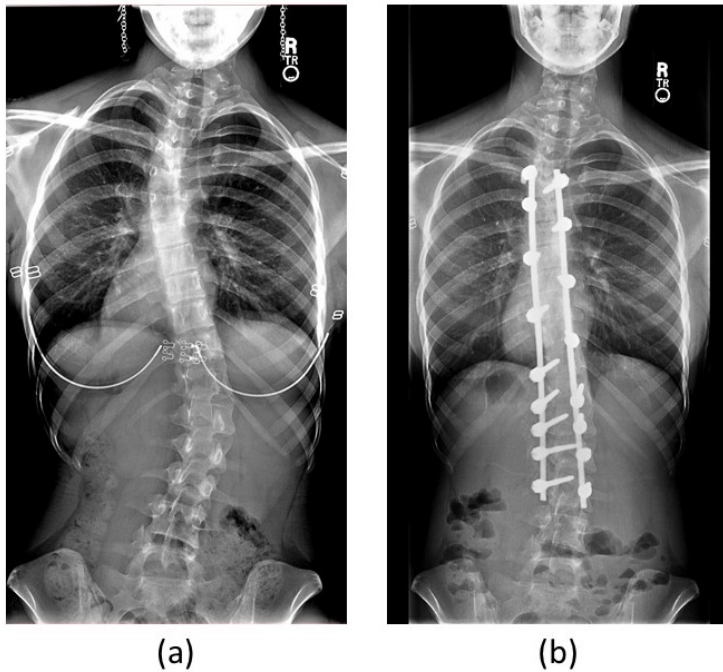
Anterior/Posterior radiographs of a patient showing (a) Scoliosis deformity of the spine, (b) curve corrected with pedicle screws and rods placed. Figure adapted from [9].
